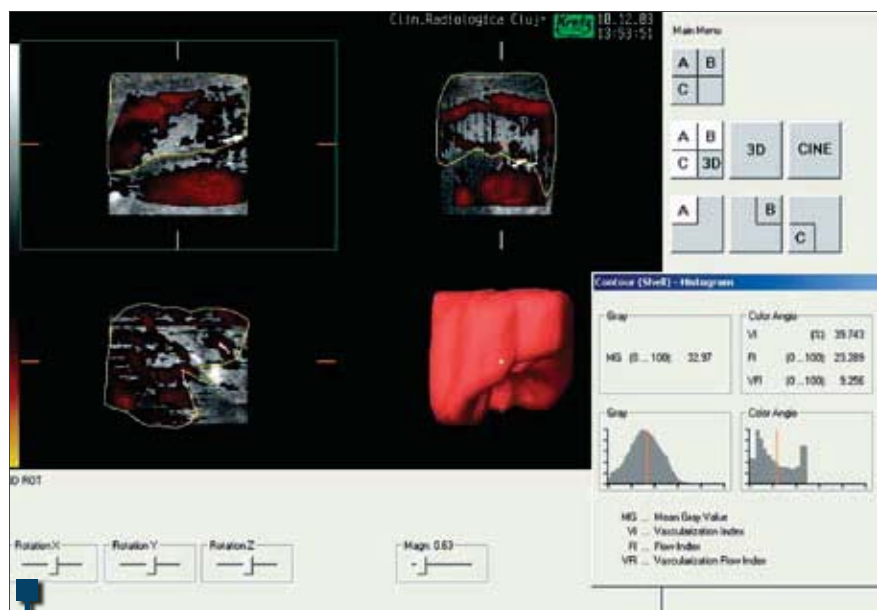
Determination of vascularization indices using the 3D power Doppler histogram
